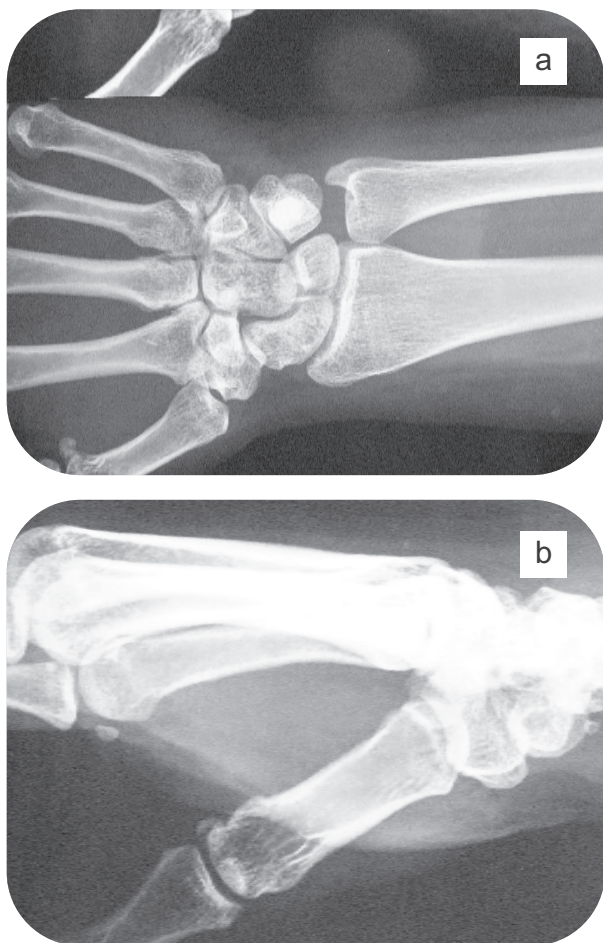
2 year post-operative AP (a) and lateral (b) radiographs of the same patients showing healed cyst after undergoing curettage and bone grafting.
